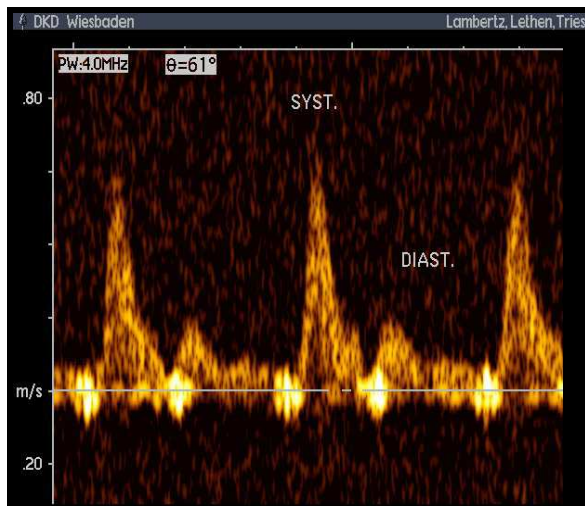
Pulsed wave Doppler profile of mammary artery. The systolic flow velocity is typically higher than the diastolic (Heinz Lambertz et al., 2004).
